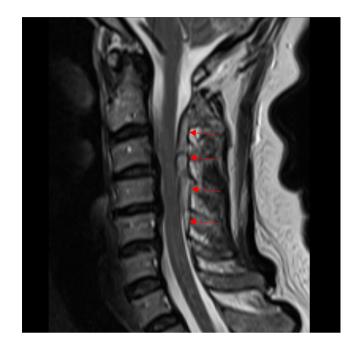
Sagittal T2-weighted cervical magnetic resonance imaging indicating a heterogeneous high-signal mass in the epidural space posterior to the spinal cord between C2 and C5 (red arrow).
